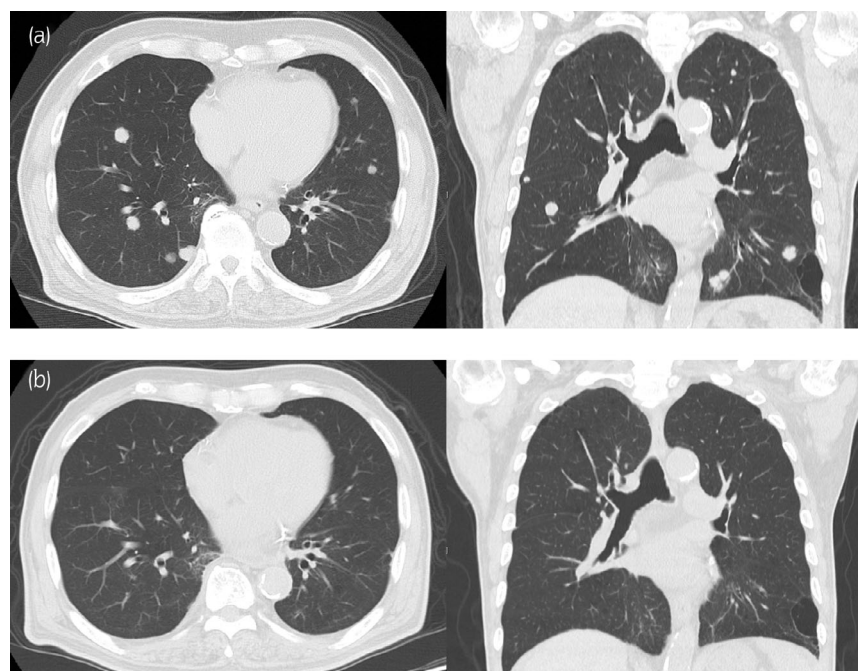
(a) After three additional chemotherapy with gemcitabine + carboplatin, CT shows multiple metastatic tumors in the lungs. (b) The end of three courses of pembrolizumab showed good progress and resolution of lung lesions.
